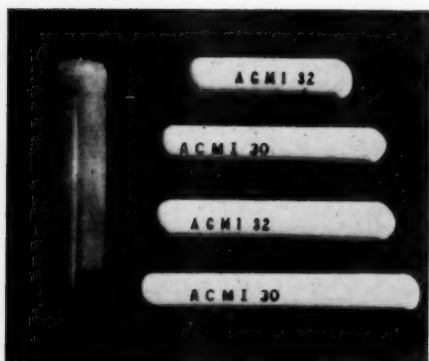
Laryngeal obturators of polyethylene tubing. Suitable size and length can be determined by x-ray measurements. The obturators are fixed to the tracheotomy tube by a heavy silk thread (see Figures 5C and 6C).
